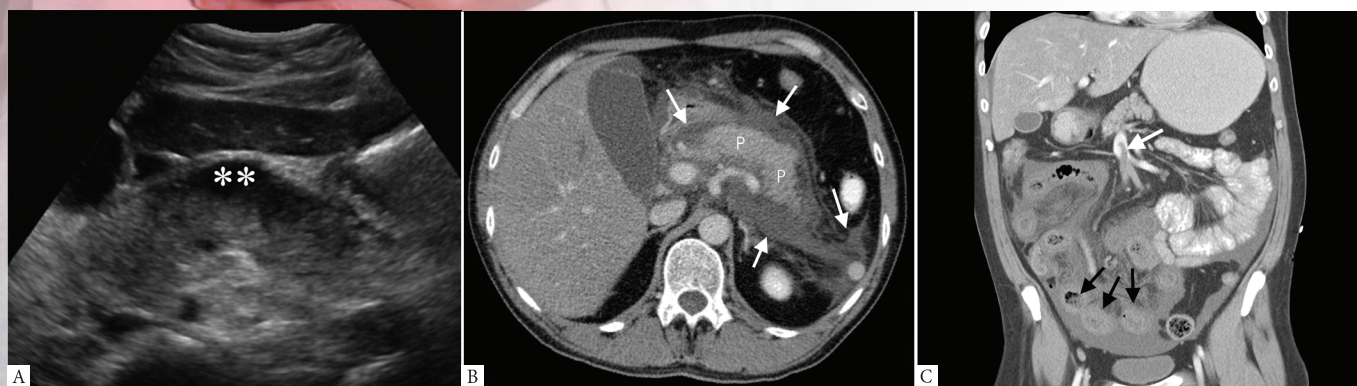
Transverse US scan of the pancreas () showing a hypoechoic focus in the neck of the pancreas. This was confirmed on CT to be due to focal pancreatitis. CT or MRI is needed to distinguish focal pancreatitis from a pancreatic neoplasm and to assess the proportion of necrotic versus viable pancreatic tissue. 1b. Contrast-enhanced CT scan showing enhancing viable segments of the pancreas (P) from necrotic components/peripancreatic fluid (arrows). 1c. Contrast-enhanced CT coronal reconstruction showing thrombus in the superior mesenteric vein (black arrow) and oedematous small bowel loops (white arrows).
